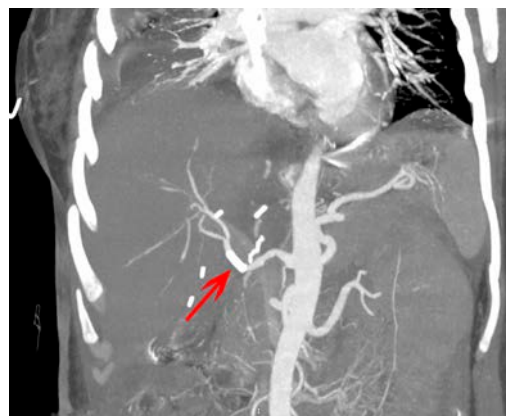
Computed tomography at 8 months after retransplantation. No findings of tumor recurrence. Hepatic artery stent (arrow) is patent
